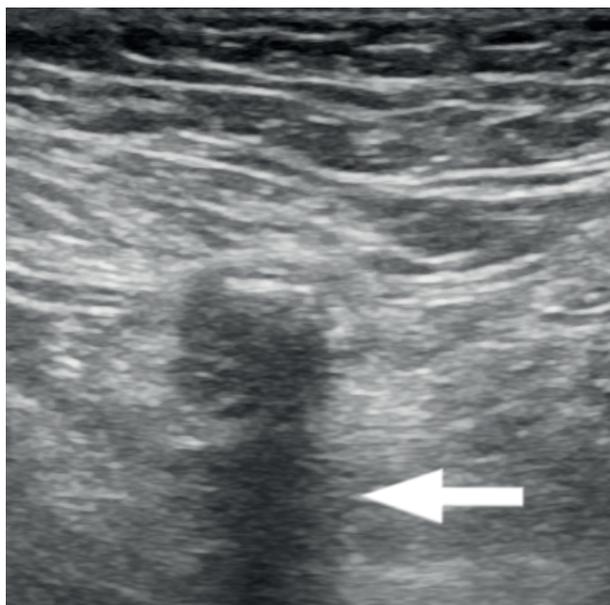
Ultrasonography of the right common femoral artery. Acoustic shadowing (arrow) produced by calcifications prohibit arterial lumen morphological analysis
